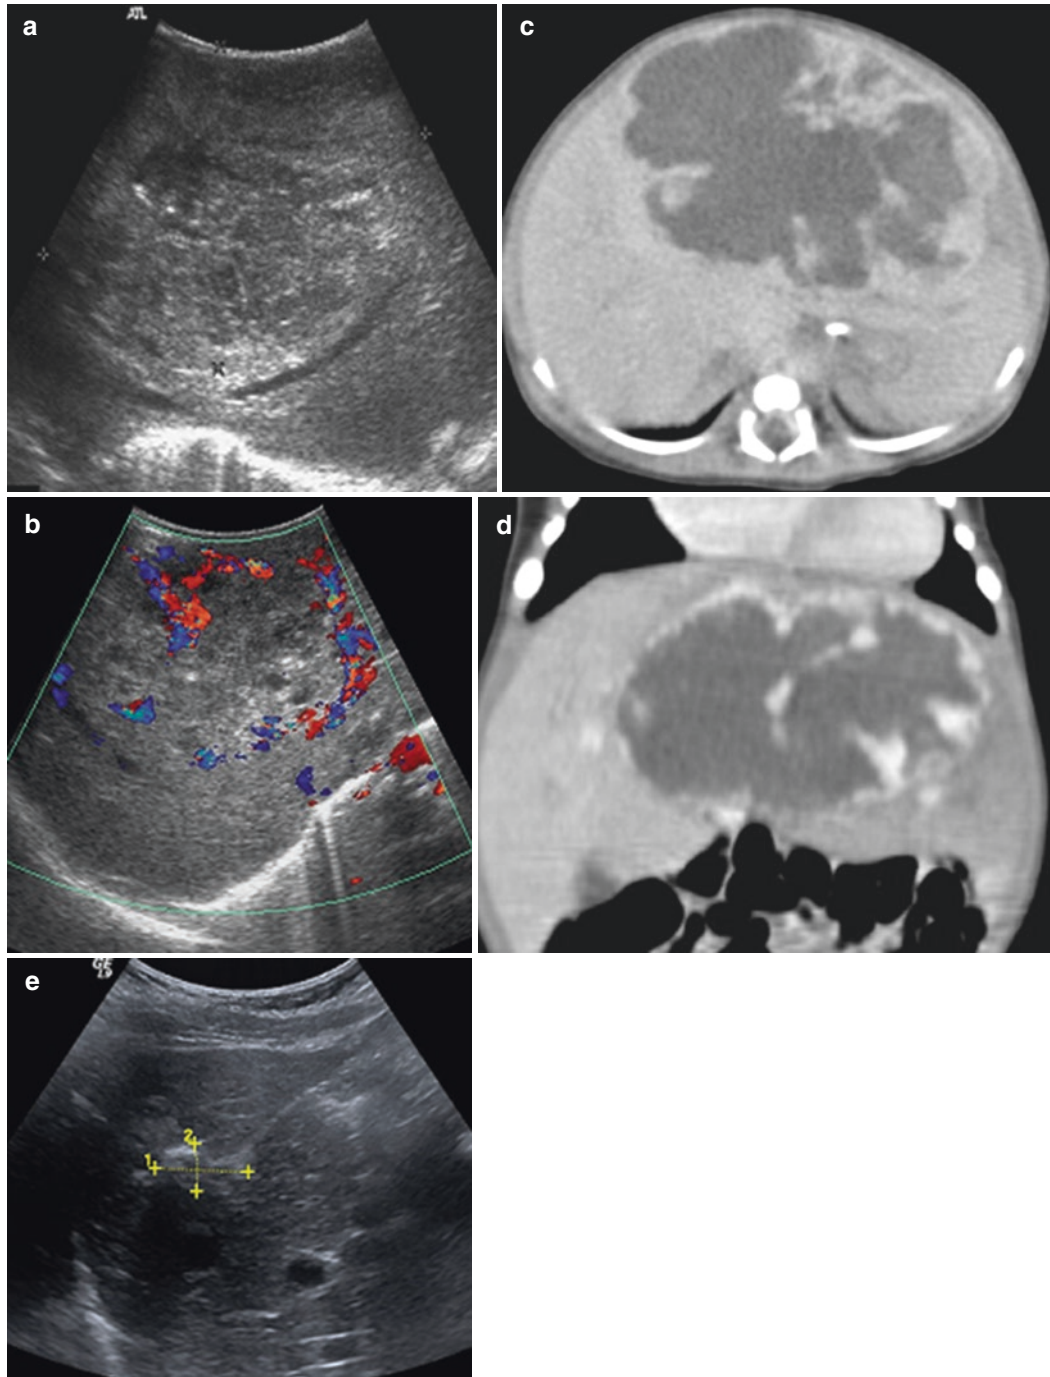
Congenital hemangioma (a) US scan large cystic mass in the left and middle areas of the liver with mixed echogenicity. (b) Doppler US flow is seen predominately around the mass. (c) CT scan show a low density lesion in the left lobe of the liver. (d) The edge of this lesion
